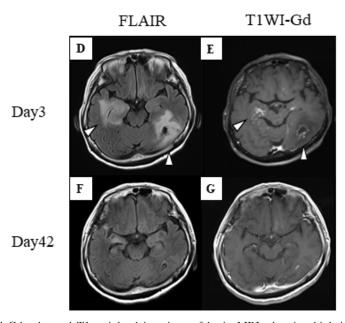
FLAIR and Gd-enhanced T1-weighted imagings of brain MRI, showing high intensity lesions with enhancement in right temporal lobe and left occipital lobe (D and E, arrowheads) on Day 3, which greatly improved on Day 42 (F and G).
